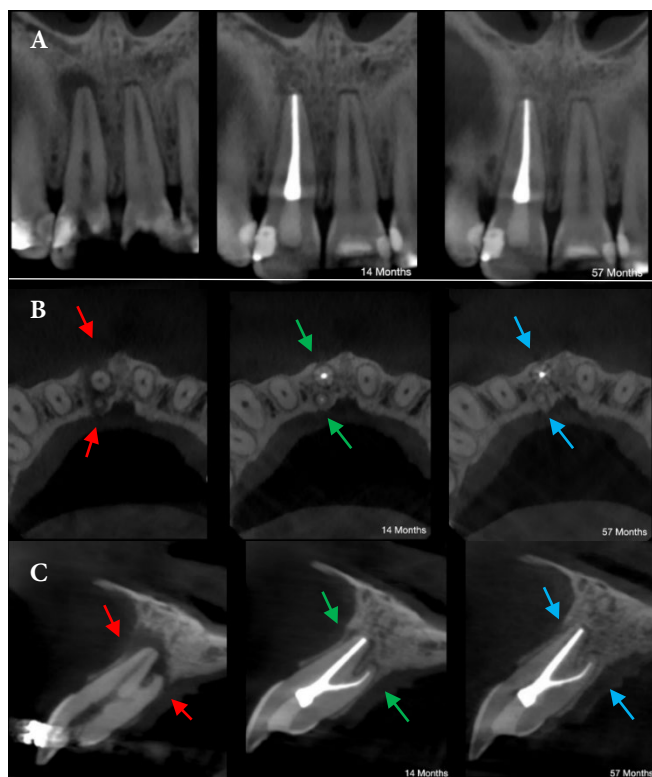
A) Comparison of CBCT images: Follow-up at 14 and 57 months. Coronal plane; B) Axial plane; C) Sagittal plane.
